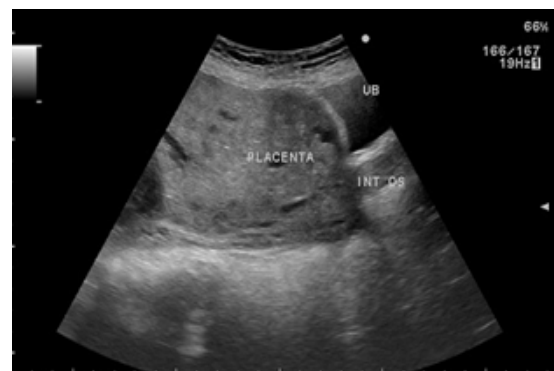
An ultrasound image in ANC 36 weeks of gestation showing placental lacunae and loss of retroplacental clear space in case of placenta accreta.
